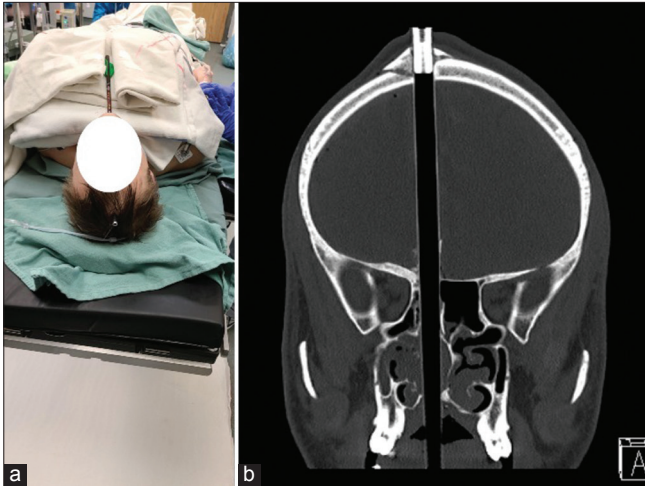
Penetrating head injury. Suicidal attempt in a 31 Y male. (a) A gross photograph of the patient showing the arrow as it enters through the floor of the oral cavity and exits through the calvarium on the right side. (b) A computed tomography scan (bone window) shows the bony defect in the skull base and the frontal bone fracture at the site of exit.
